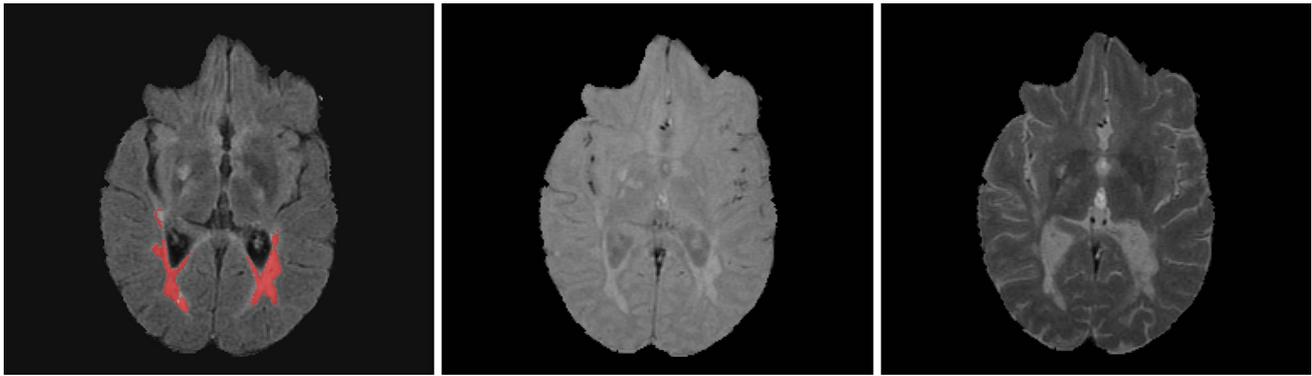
Left axial slice of the FLAIR image with semi-automatic lesion segmentation highlighted in red. Middle proton density weighted image. Right T2-weighted image. See text for details
